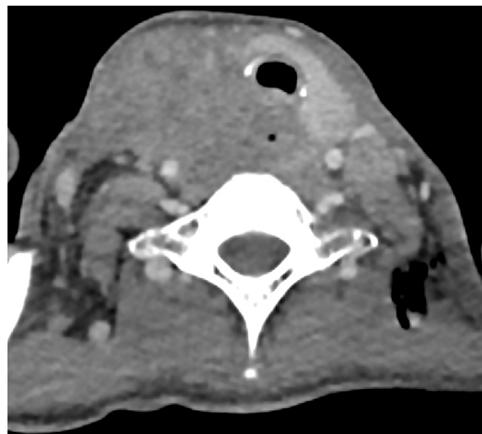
Axial CT scan showing a hypopharyngeal mass extending to the right thyroid gland, oesophagus and prevertebral muscle with anterolateral displacement of the trachea and subcutaneous emphysema.
